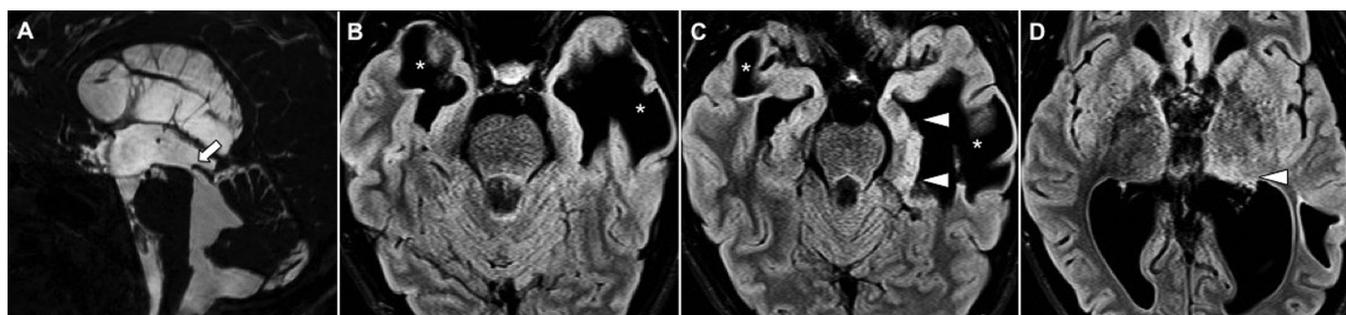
MRI high-resolution sagittal T2-weighted sequence (A) shows severe stenosis at the upper portion of the cerebral aqueduct (arrow) in a background of noncommunicating hydrocephalus. Fluid-attenuated inversion recovery (FLAIR) images (B–D) show pronounced dilatation of the lateral and third ventricles with intraparenchymal ventricular diverticula arising from the temporal horns of lateral ventricles (B and C, asterisk). The ventricular diverticulum on the right is limited to the temporal lobe anteriorly, whereas the more extensive left ventricular diverticulum extend into the inferior parietal lobule (asterisk). Increased T2 FLAIR signal intensity of the pulvinar of the left thalamus (C, arrowheads) and the left hippocampus (D, arrowhead) are consistent with peri-ictal changes.
